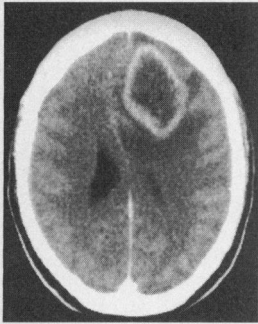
Computed tomography with enhancement easily revealed this left frontal glioma presenting with short history of dysphasia and hemiparesis in 49 year old man; he died one month after radiotherapy
